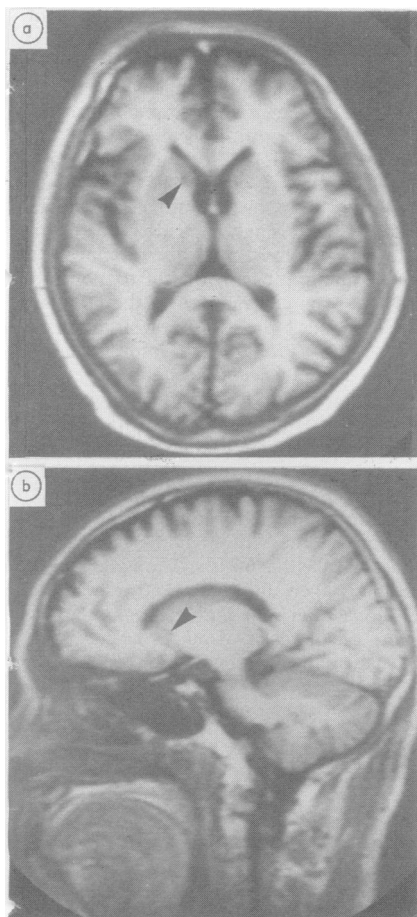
Fig MRI (92 days after symptom onset) (inversion recovery technique). (a) Horizontal view [time of repetition (TR) 2080 ms, time of inversion (TI) 500 ms], (b) Left lateral sagittal view (10 mm from midline) (TR 2080 ms, TI 500 ms), showing a small low intensity area at the head of the left caudate nucleus (arrows).
